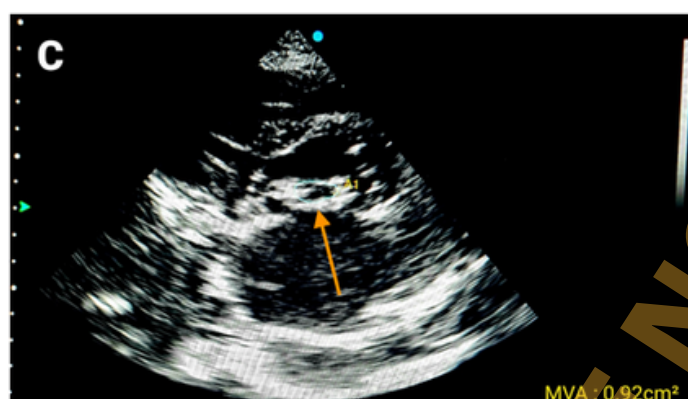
(C) Transthoracic echocardiogram in short axis view showed a several mitral stenosis with a valve area of 0.9 cm².
